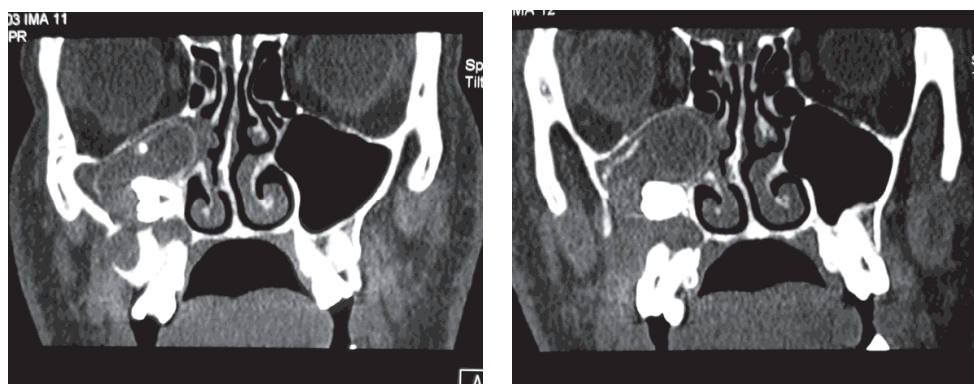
Coronal CT scan of keratocystic odontogenic tumor of the right maxilla invading the maxillary sinus and resulting in secondary inflammation of antral mucosa.
